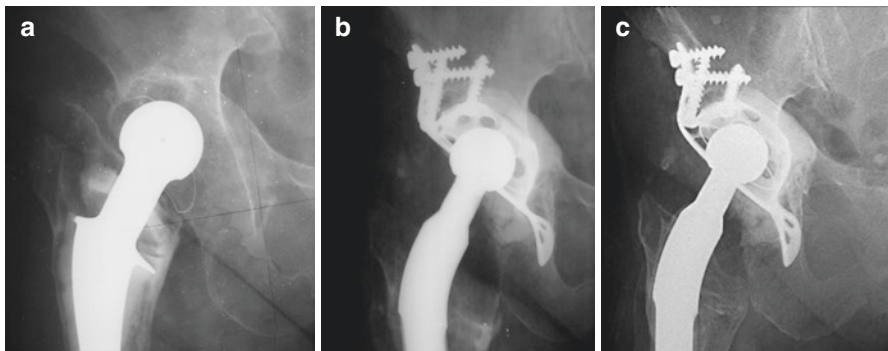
(a) Radiograph showing aseptic loosening both components in a 69 year-old woman with rheumatoid arthritis. (b) Post-operative radiograph with a BSAC without graft and Wagner stem. (c) X-ray control at 12 years. Good clinical situation
